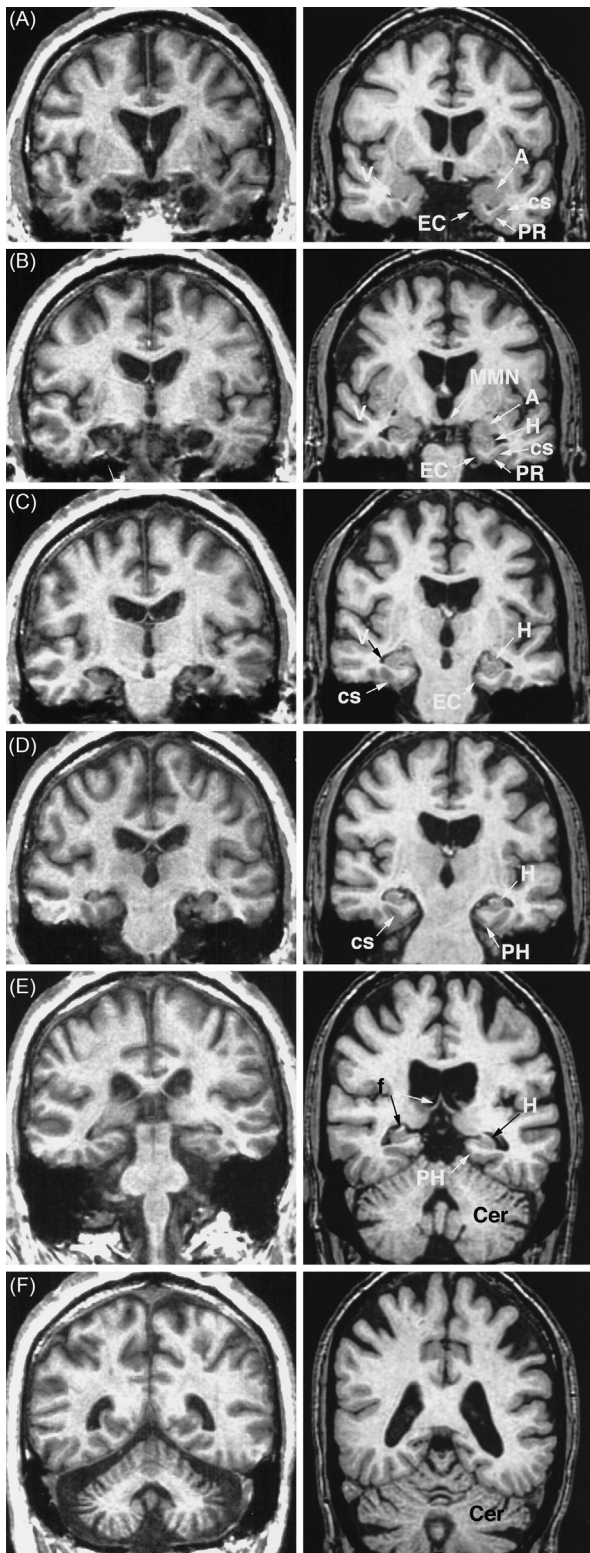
T1-weighted MR images of the brain of H.M. (left side) and an age- and education-matched control subject (right side). Labels on the control images identify regions that are damaged or missing in H.M. (A, amygdala; CS, collateral sulcus; EC, entorhinal cortex; PR, perirhinal cortex; MMN, medial mammillary nuclei; H, hippocampus; V, ventricle). Source: Adapted from *Corkin et al. (1997)*.
